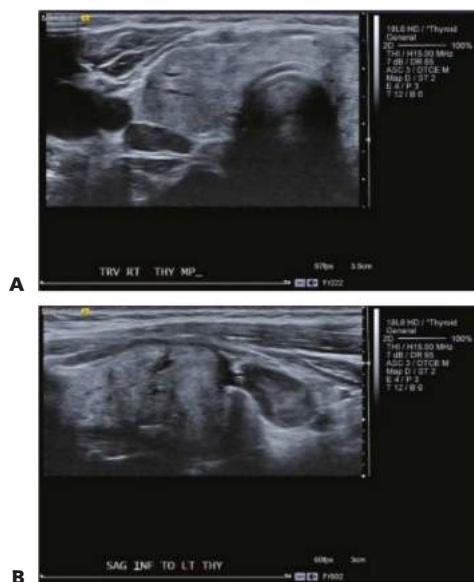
• High-resolution cervical ultrasound demonstrating clear parathyroid adenomata. A. Right thyroid lobe with a hypoechoic right upper parathyroid adenoma in the tracheoesophageal groove. B. Sagittal ultrasound view of the left thyroid lobe with a hypoechoic left inferior parathyroid adenoma.
